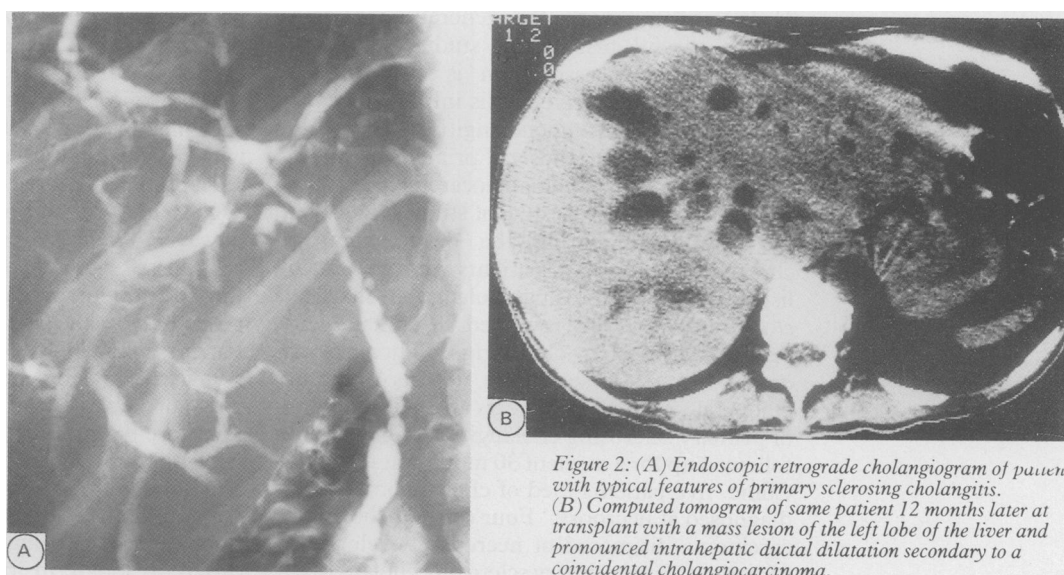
(A) Endoscopic retrograde cholangiogram of patient with typical features of primary sclerosing cholangitis. (B) Computed tomogram of same patient 12 months later at transplant with a mass lesion of the left lobe of the liver and pronounced intrahepatic ductal dilatation secondary to a coincidental cholangiocarcinoma.
